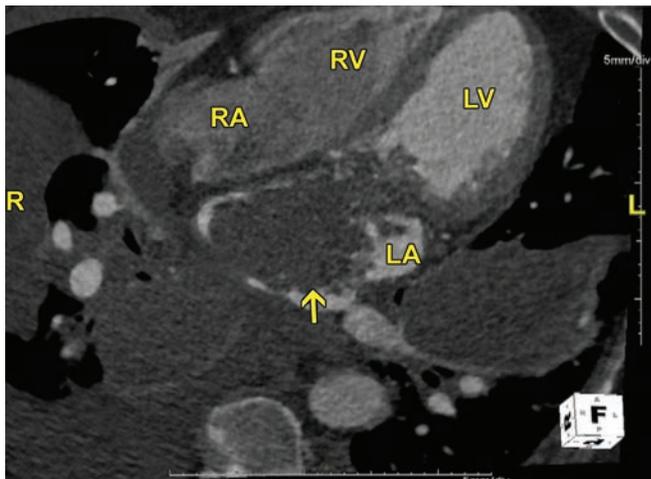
Computed tomography (CT) with contrast. Arrow points to the mass occupying most of LA.
